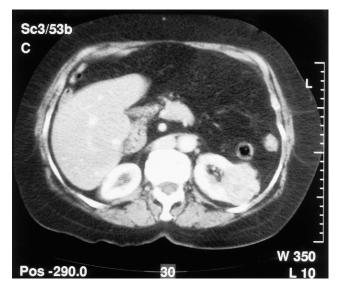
Axial CT post-intravenous contrast medium administration demonstrating the tumour arising from the left kidney.
